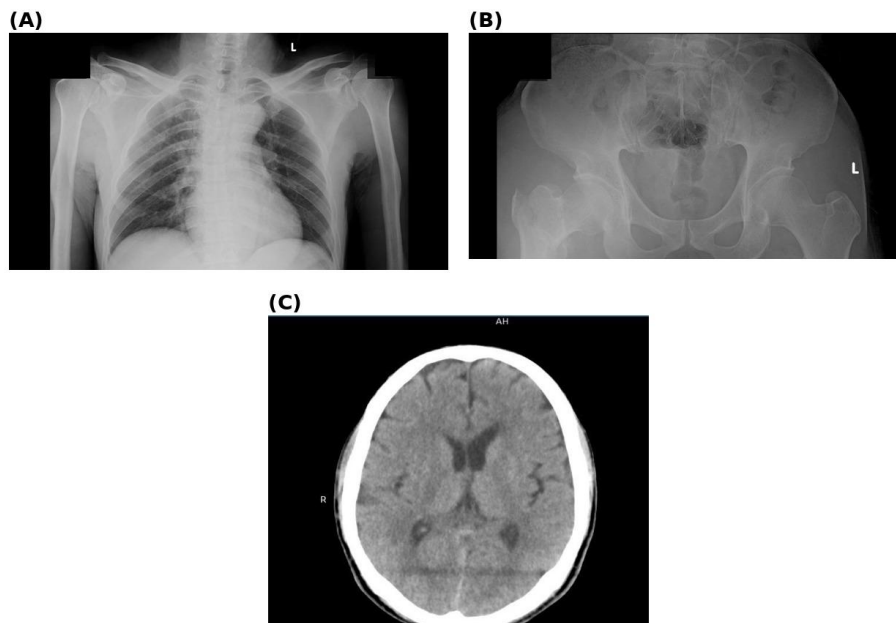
Admission imaging. (A) Chest radiograph showing no cardiopulmonary abnormality. (B) Anteroposterior pelvic radiograph demonstrating a complete, displaced intertrochanteric fracture of the right femur (Boyd-Griffin type II). (C) Representative axial slice of the non-contrast head MSCT; the sub-centimetre right frontal hemorrhage was identified on a separate slice. Patient identifiers have been redacted to preserve confidentiality.
